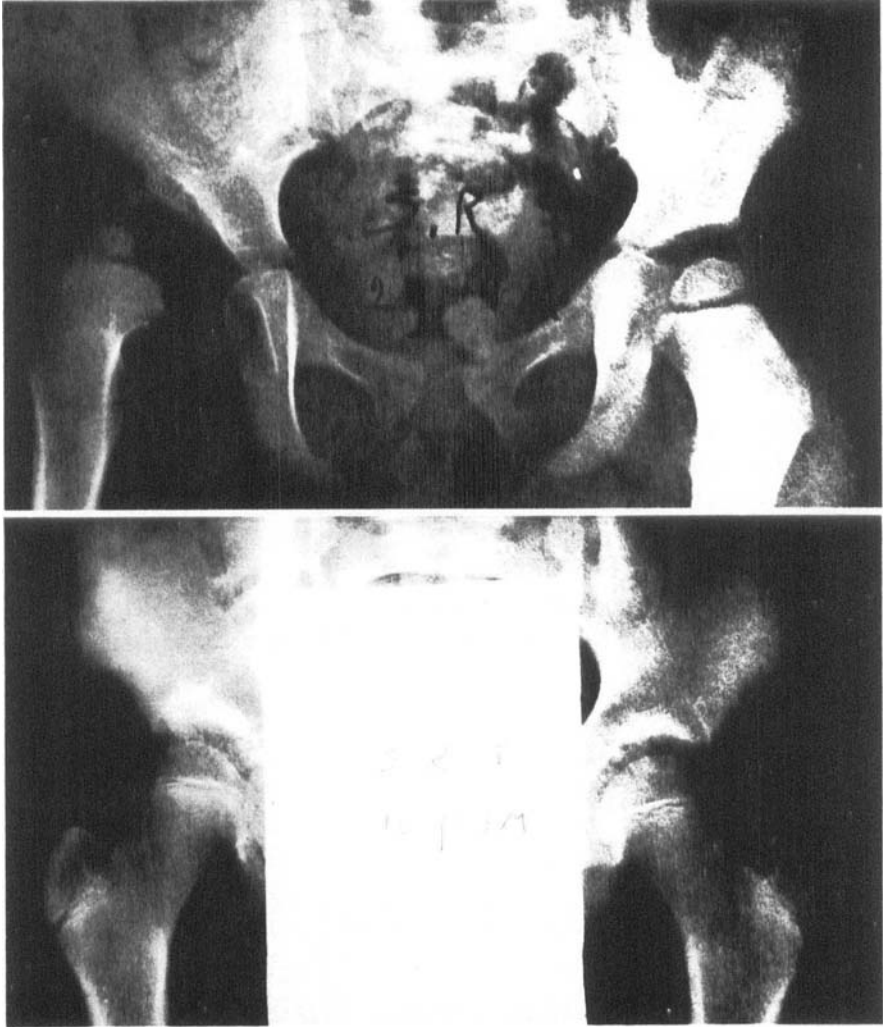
Middle-high dislocation, diagnosed at 2 years 4 months, treated by closed reduction and plaster for 7 months. The last X-ray at 10 years 3 months considered as "practically normal".
